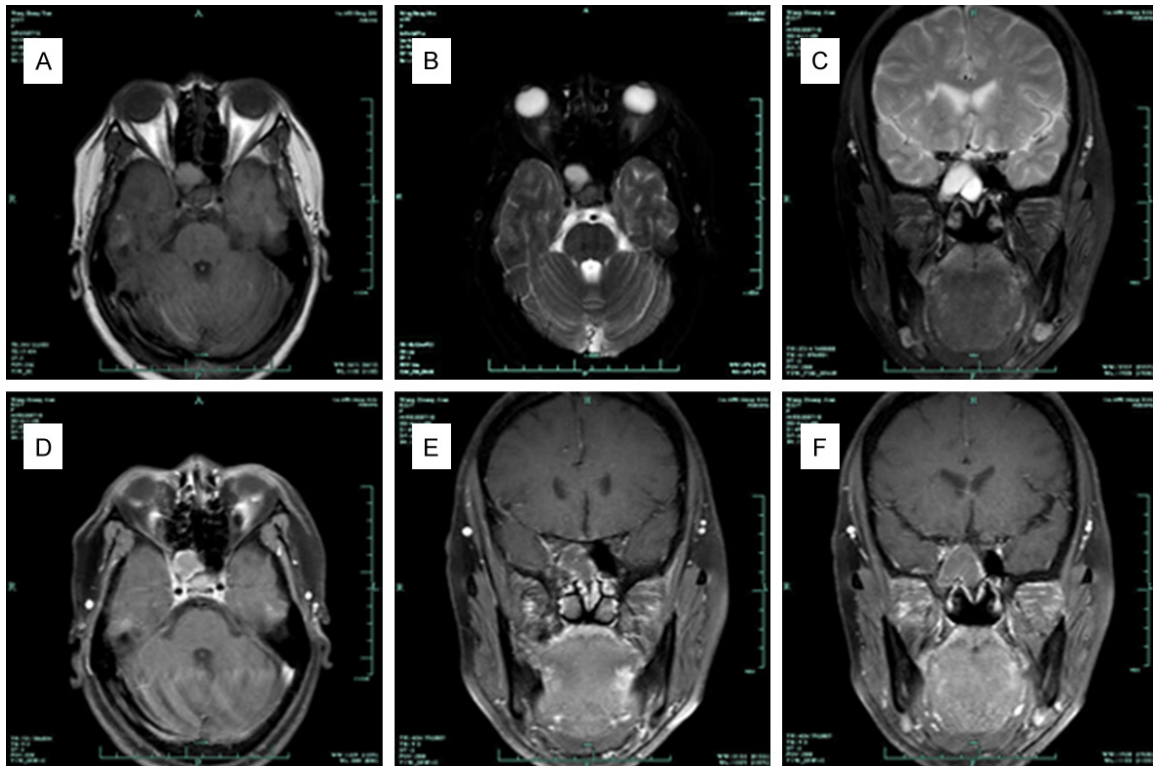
Magnetic resonance imaging (MRI) of the paranasal sinuses showed little high intensity on T1-weighted (A) and marked intensity on T2-weighted imaging (B, C) with Lesions rim enhanced significantly after gadolinium injection (D-F).
